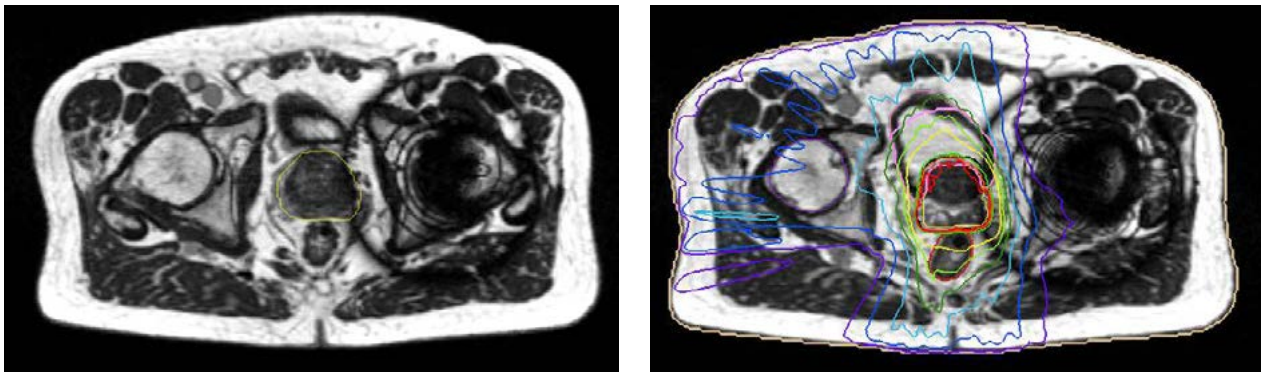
The MRIdian treatment plan with prostate contour on the planning MRI scan shown on the left and the prostate plan achieved on the right
